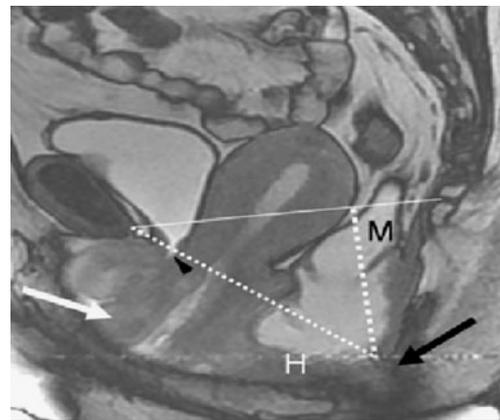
Severe uterine prolapse in a 41-year-old woman. Sagittal function MRI image obtained during defaecation shows the uterus moving downward inside the vagina and the cervix exits the vaginal introitus (white arrow). *H* and *M* lines are abnormally elongated. The vagina appears shortened and everted; this finding is associated with the change in cervix-fundus angulation and flexion. Urethral funneling without hypermobility (arrowhead) and severe (7 cm) posterior compartment descent (black arrow) are also seen (with permission from Colaiacomo et al. [72])
